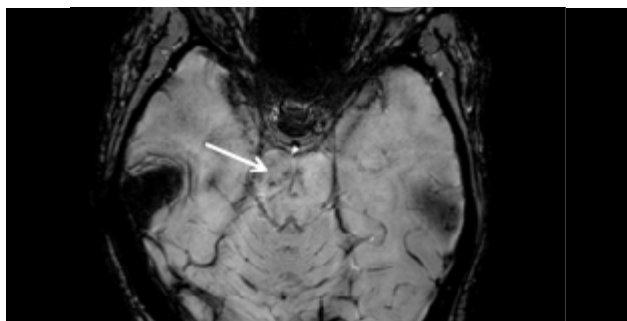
MRI of a 36-year-old woman presenting with sudden-onset ataxia, dysarthria, cranial neuropathy, and cerebellar dysfunction. Axial susceptibility-weighted imaging sequence showing hemorrhagic foci in the midbrain (arrow), together with prominent venous structures in the vicinity of the lesion.
